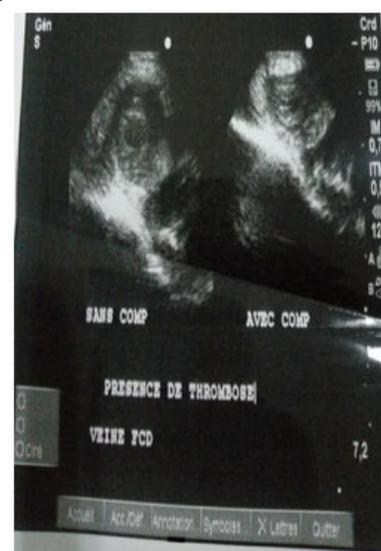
Venous doppler echo shows the presence of acute extensive deep vein thrombosis of the sural vein extended to the popliteal vein and the superficial femoral vein with thrombus head at the level of the right iliac vein.
